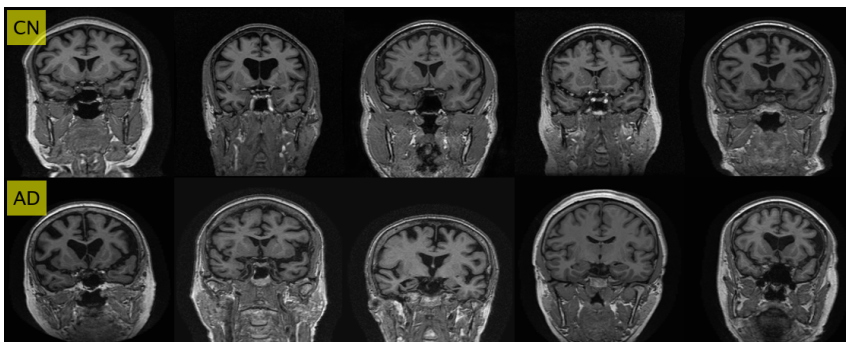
Coronal plane: MRI slice Nr. 101 for CN and AD. Best selection according to pre-trained CNN features.
